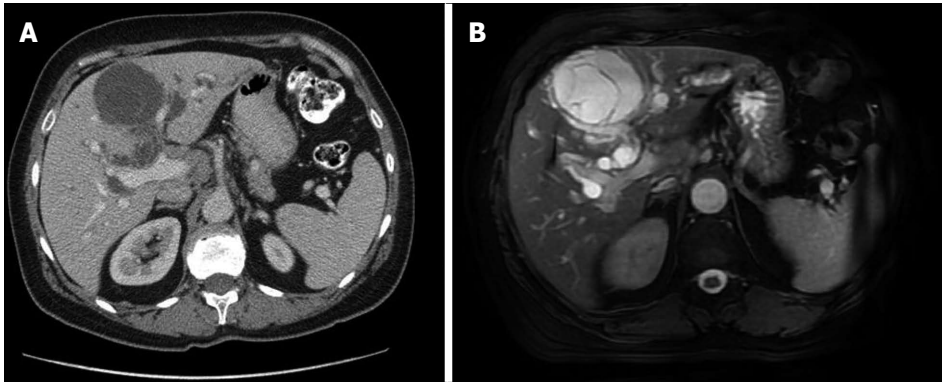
Computed tomography scan and T1-weighted magnetic resonance imaging. A: Computed tomography scan (portal phase) shows a hepatic cystic tumor with thin contrast-enhanced septum and dilated intrahepatic bile ducts; B: T1-weighted magnetic resonance imaging of the tumor presents a hyperintense, multiseptal cystic lesion that does not communicate with the bile ducts.
